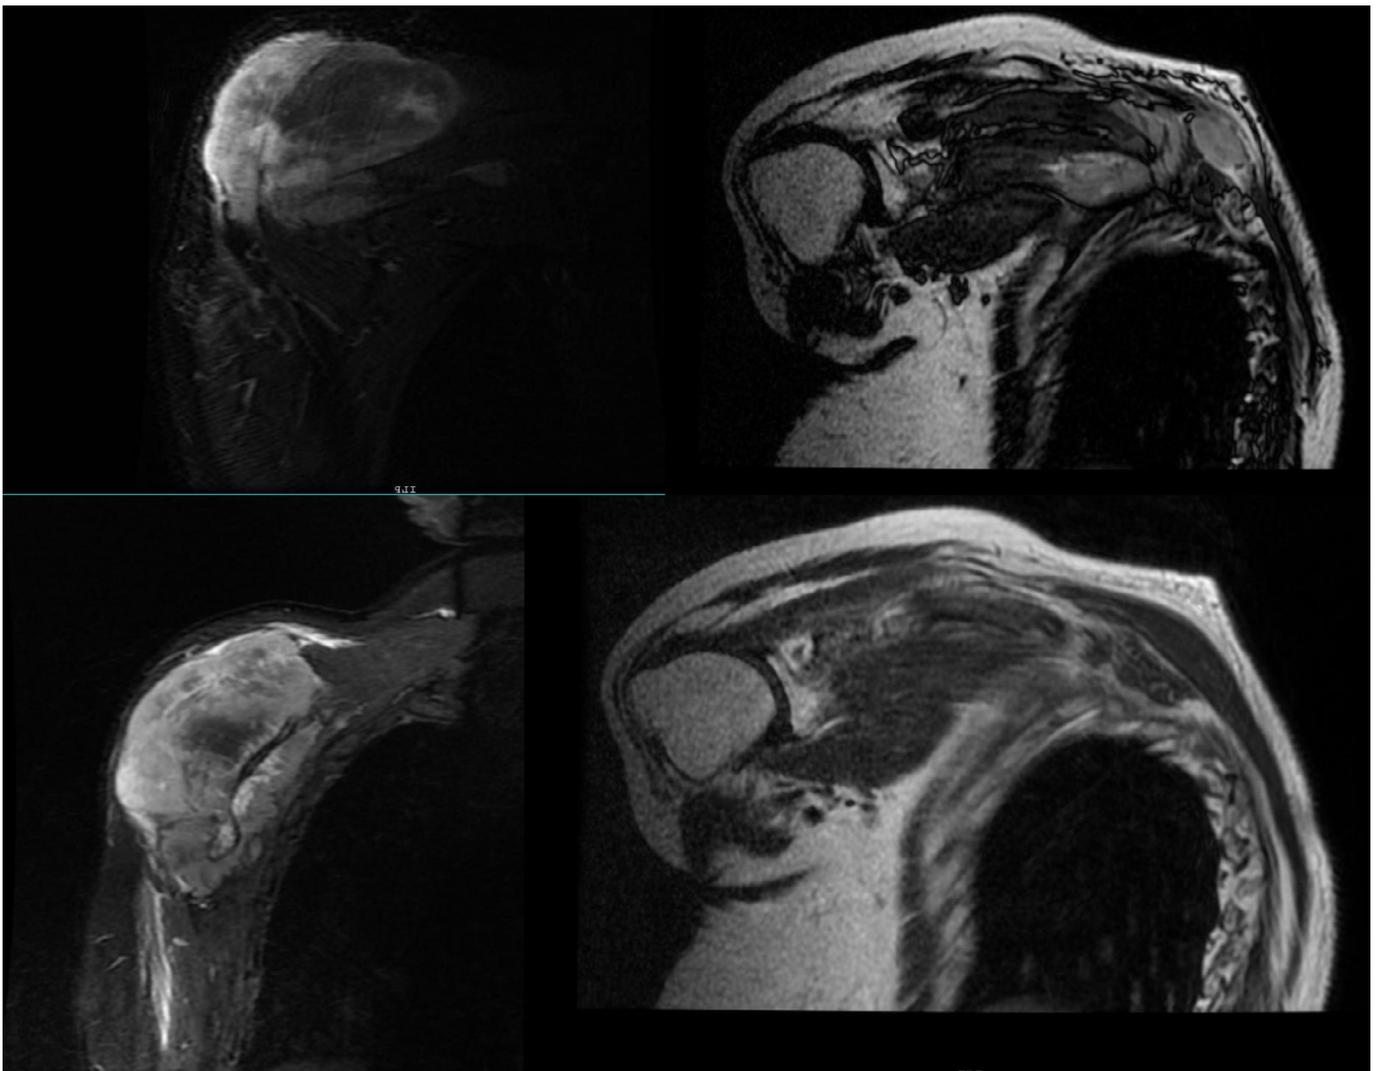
MRI images of the right scapular tumor
